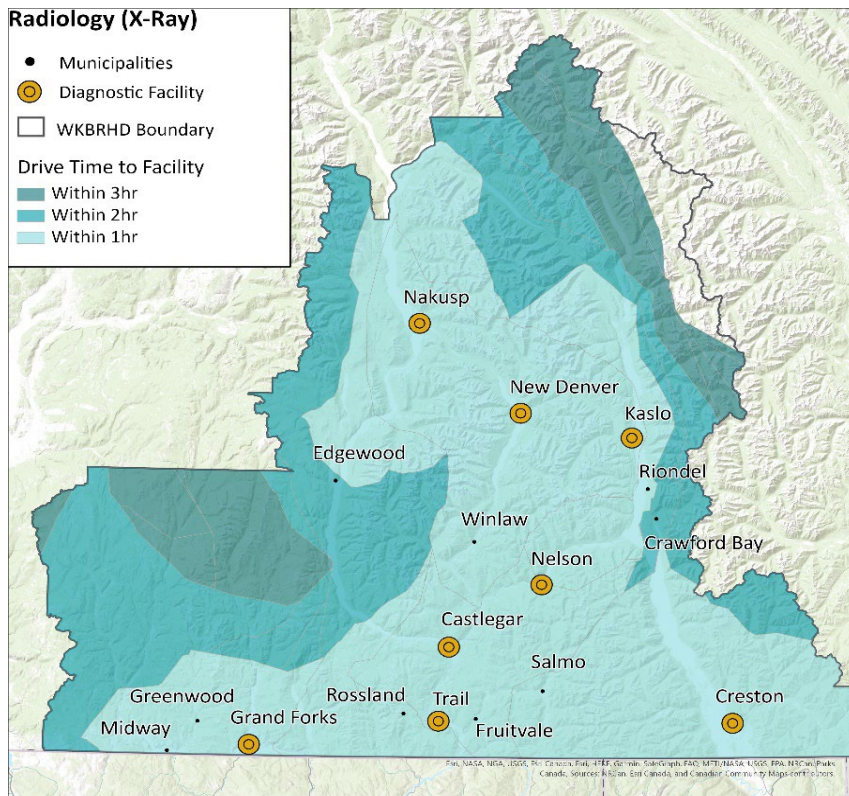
Service area distances to radiology (X-Ray) diagnostic facilities within the WKBHRD
